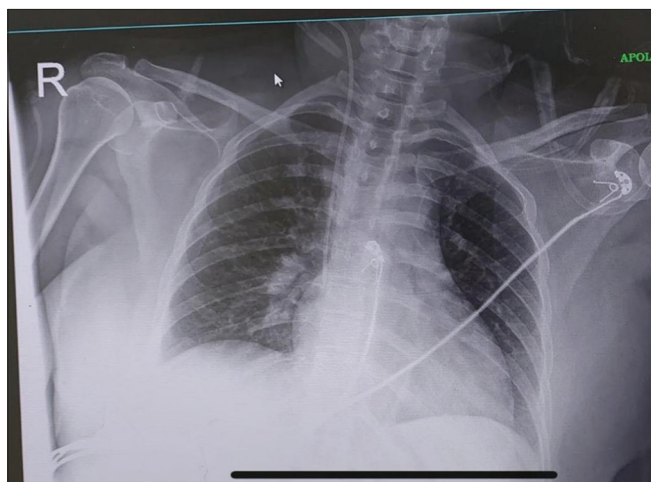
Chest X-ray PA view during admission
